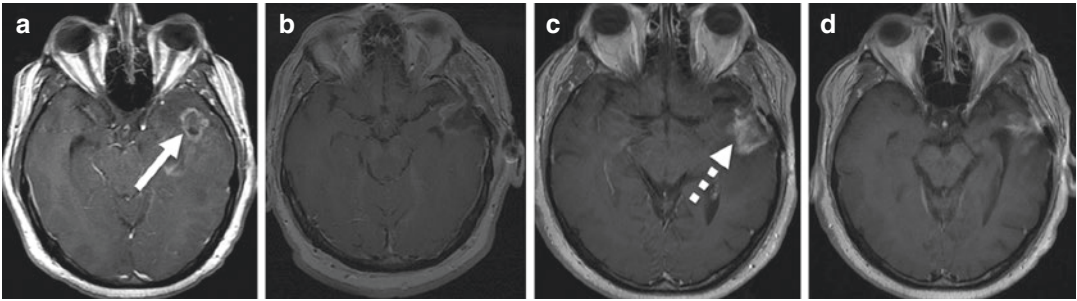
Pseudoprogression involving MGMT-methylated glioblastoma. (a) Preoperative contrast T1-weighted image demonstrates a rim-enhancing left temporal lobe mass (arrow). (b) Postoperative contrast T1-weighted image demonstrates milder enhancement before the initiation of XRT/TMZ therapy. (c) At 2-month follow-up after chemoradiation, contrast T1-weighted image
